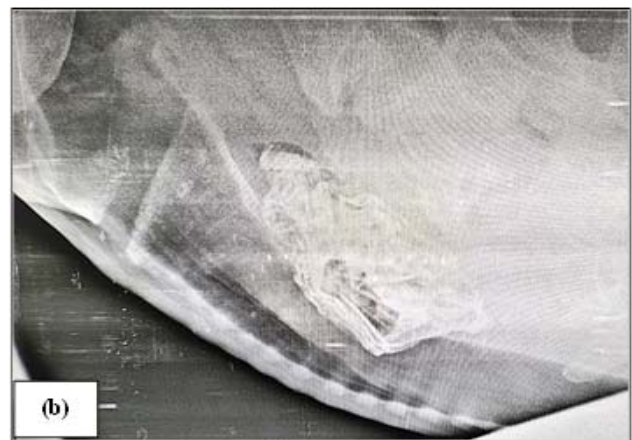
b) Left lateral cranial-cervical radiograph presence of a radiopaque foreign body (tarpaulin) within the esophageal lumen, accompanied by significant compression of the tracheal wall in Case 2.
